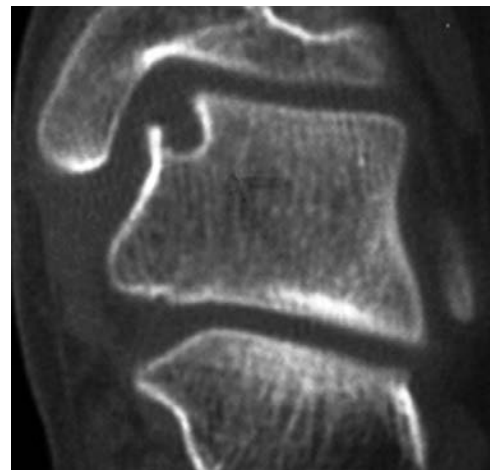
This CT scan clearly shows a well-circumscribed cyst at the base of a stage II osteochondral lesion. This would be classified by Anderson et al.⁸ as a stage IIa lesion.
